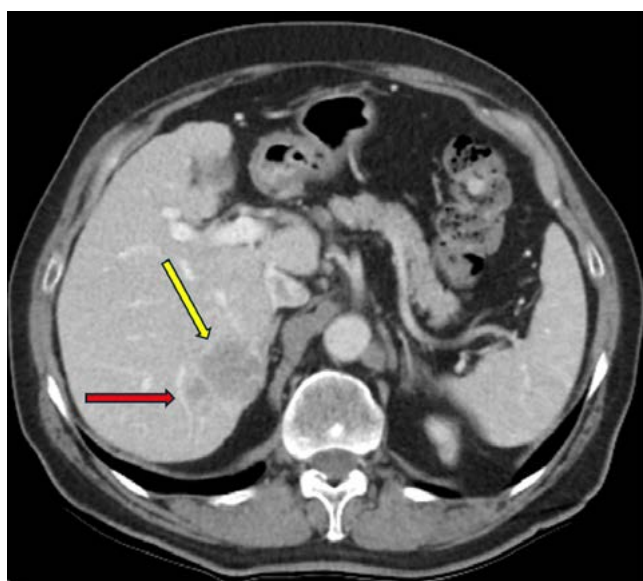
Pre-transplant liver CT: contrast-enhanced axial CT shows two hypodense lesions in hepatic segment VI, consistent with HCC. The dominant lesion is indicated with a yellow arrow, and the smaller adjacent lesion is indicated with a red arrow
